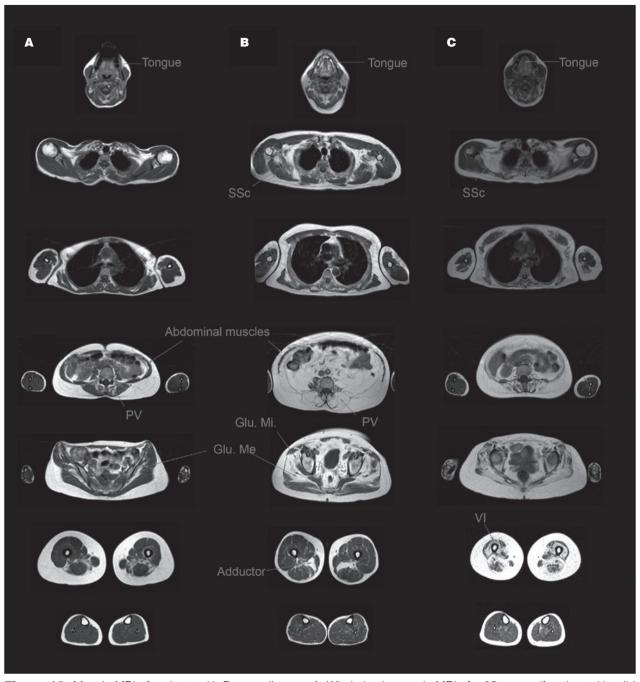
Muscle MRI of patients with Pompe disease. A: Whole body muscle MRI of a 35 years olf patient with mild muscle involvement showing atrophy of tongue, paravertebral and abdominal muscles, gluteus medius (Glu.Me) and posterior muscles of the thighs. B: Muscle MRI of a 43 years old patients with moderate weakness showing involvement of tongue, subscapularis (SSc), paravertebral and abdominal muscles, gluteus medius (Glu.Me) and gluteus minimus and adductor major (AM). C: Muscle MRI of a 44 years old patients with severe weakness showing involvement of tongue, subscapularis (SSc), paravertebral, abdominal, all glutei muscles and anterior and posterior muscles of the thighs.
